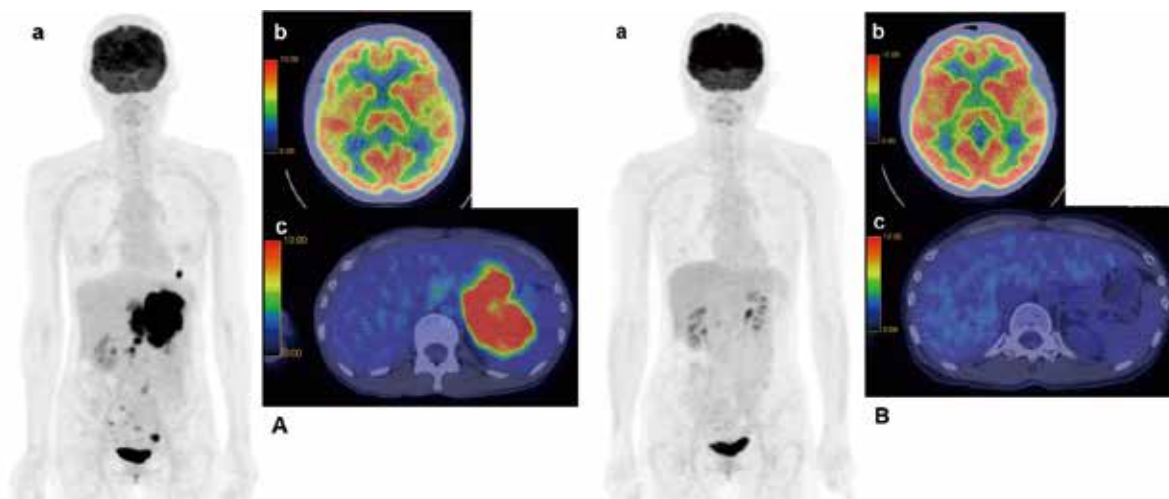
The increase and recovery of brain and liver uptake with decreasing tumor uptake after chemotherapy. FDG PET/CT images of the case in which had showed decreased brain and liver uptake with high uptake in the lesions of tumor of DLBCL (A), which showed the uptake of brain and liver increase and recovery with decreasing uptake of tumor after chemotherapy (B). Maximum intensity projection of FDG PET (a), PET/CT fusion image of brain (b), PET/CT fusion image of liver (c) of a 40-year-old female. A: Each parameter follows; SUVmax of 2.9, SUVmean of 2.2 in liver, SUVmax of 12.3, TGV of 6896.1 in brain. B: Each parameter follows; SUVmax of 3.0, SUVmean of 2.4 in liver, SUVmax of 14.7, TGV of 8054.2 in brain.
